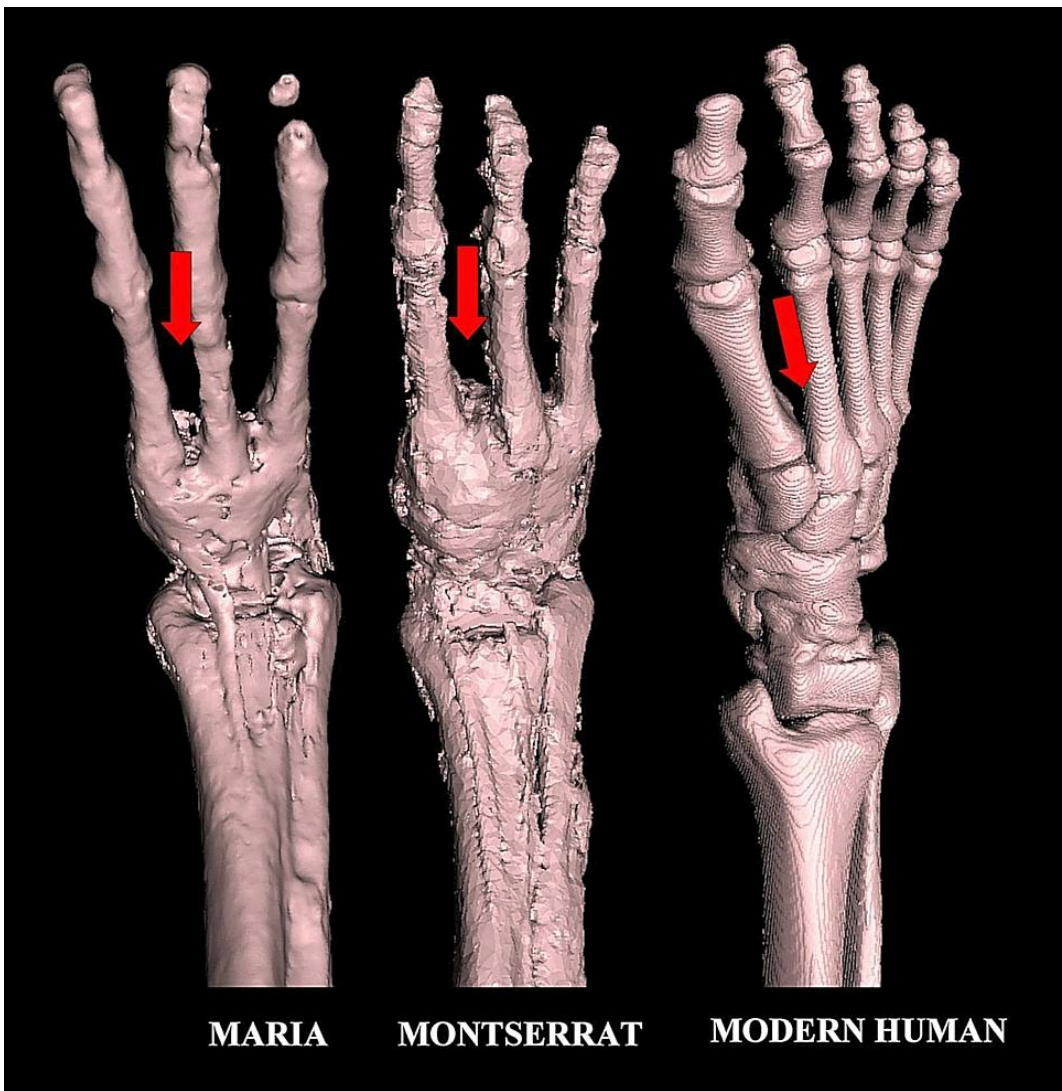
Comparison of 3D CT showing bones of right foot of Maria (*left*), Montserrat (*middle*) and modern human (*right*). Note the wide gap (*red arrows*) between all digits in Maria and Montserrat but only in big toe in modern human. The bones in digits also showed difference in length, diameter and shape. The tarsal bones appeared more compact in Maria and Montserrat than human.
